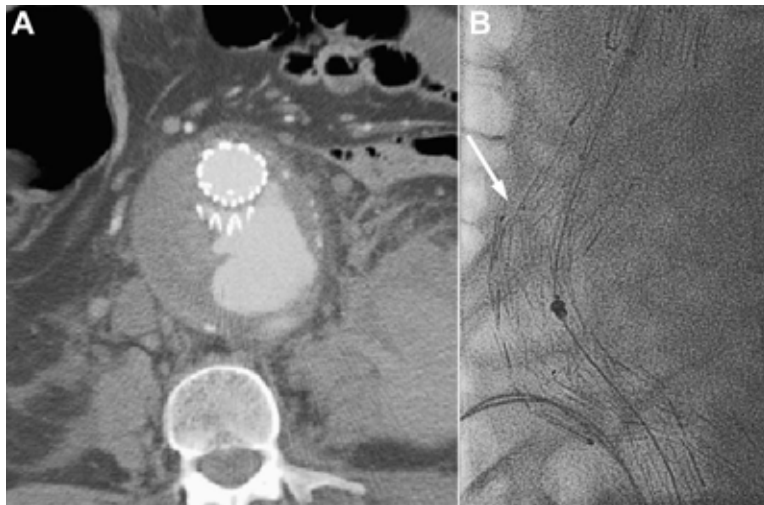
♦ AAA rupture after type III endoleak of a fenestrated Zenith stent-graft in an 81-year-old patient. (A) CT scan on admission shows the endoleak at the spot of the separated proximal and distal segments and an extensive retroperitoneal hematoma. (B) Intraoperative fluoroscopy in lateral projection shows the 50-mm-long iliac extension before deployment to bridge the 2 separated components (arrow).
